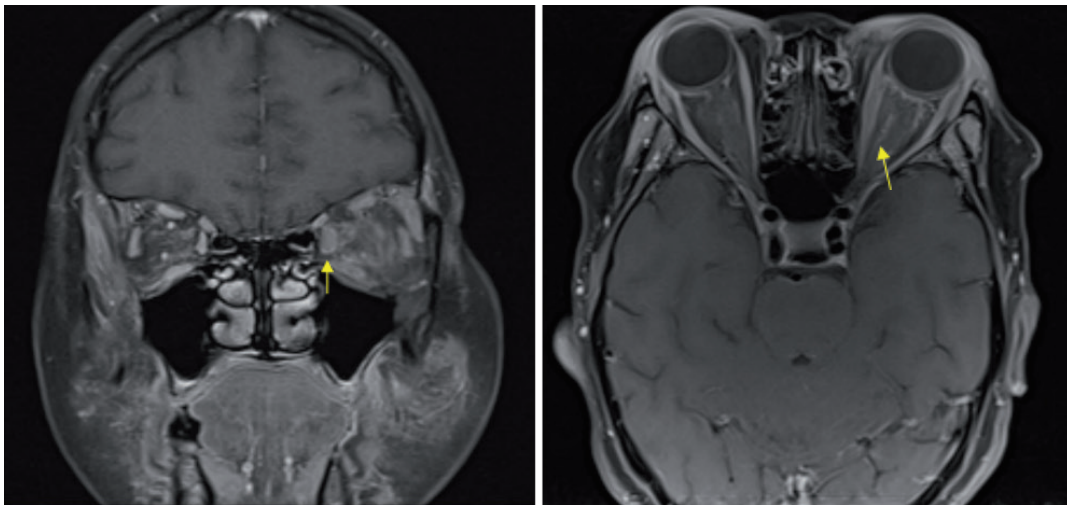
(right): Noted left bulky EOM and optic nerve compare to right EOM in MRI orbit
